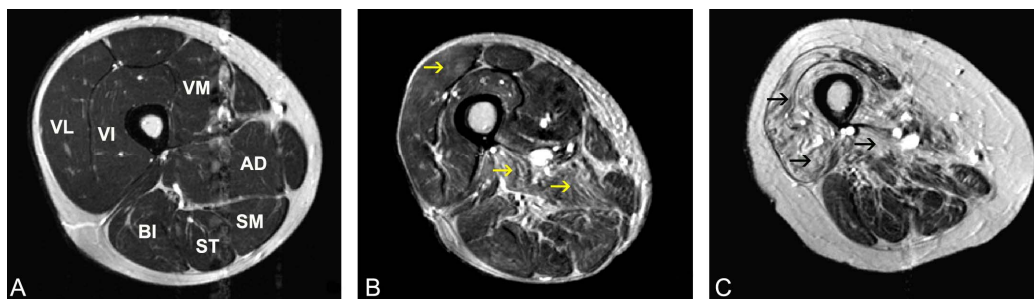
T2-weighted images of the thigh of (A) normal control, (B) PM patient with inflammation (arrows), and (C) PM patient with fat infiltration (arrows).
